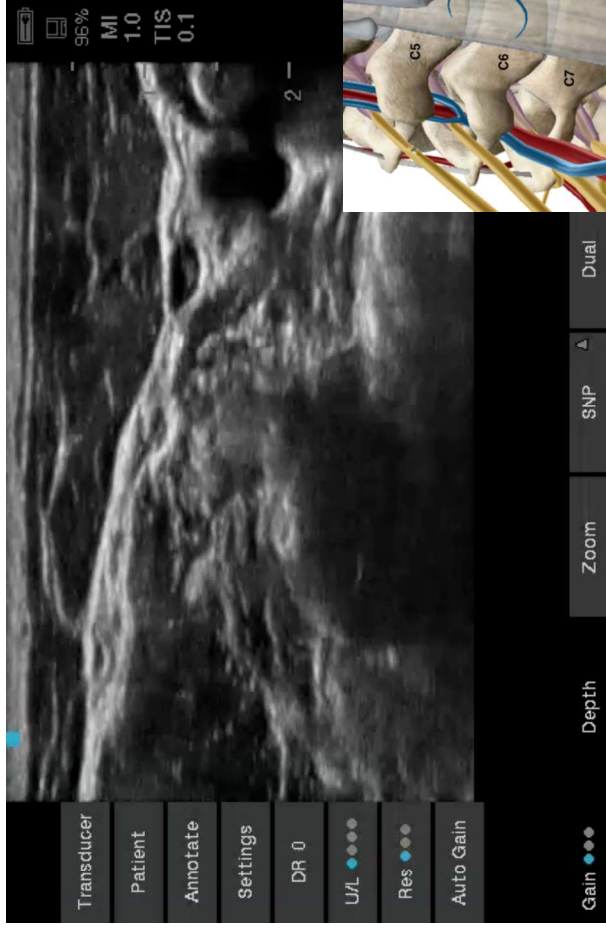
Ultrasound-anatomy correlation of the stoplight sign. A, Depiction of a short segment of roots of C5 and C6 as they converge to form the upper trunk (UT). The splitting of C6 is clear after removal of the epineurium. B, Ultrasound image depicting the stoplight sign formed by 3 hypoechoic dots between the anterior scalene (AS) and the middle scalene (MS) muscles.
